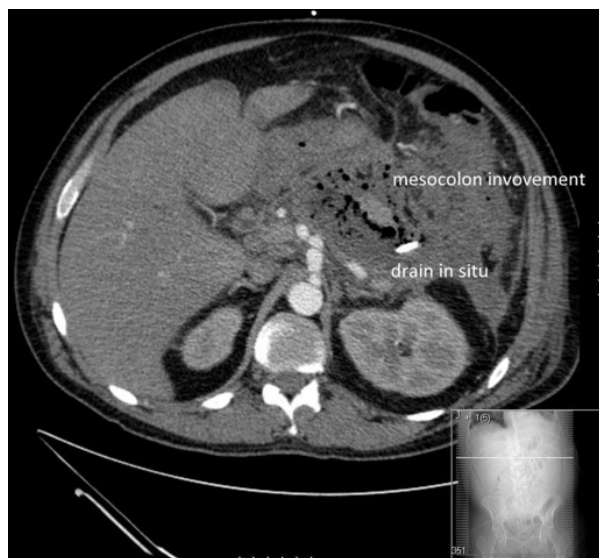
CT scan image showing involvement of mesocolon by pancreatic inflammatory process.
